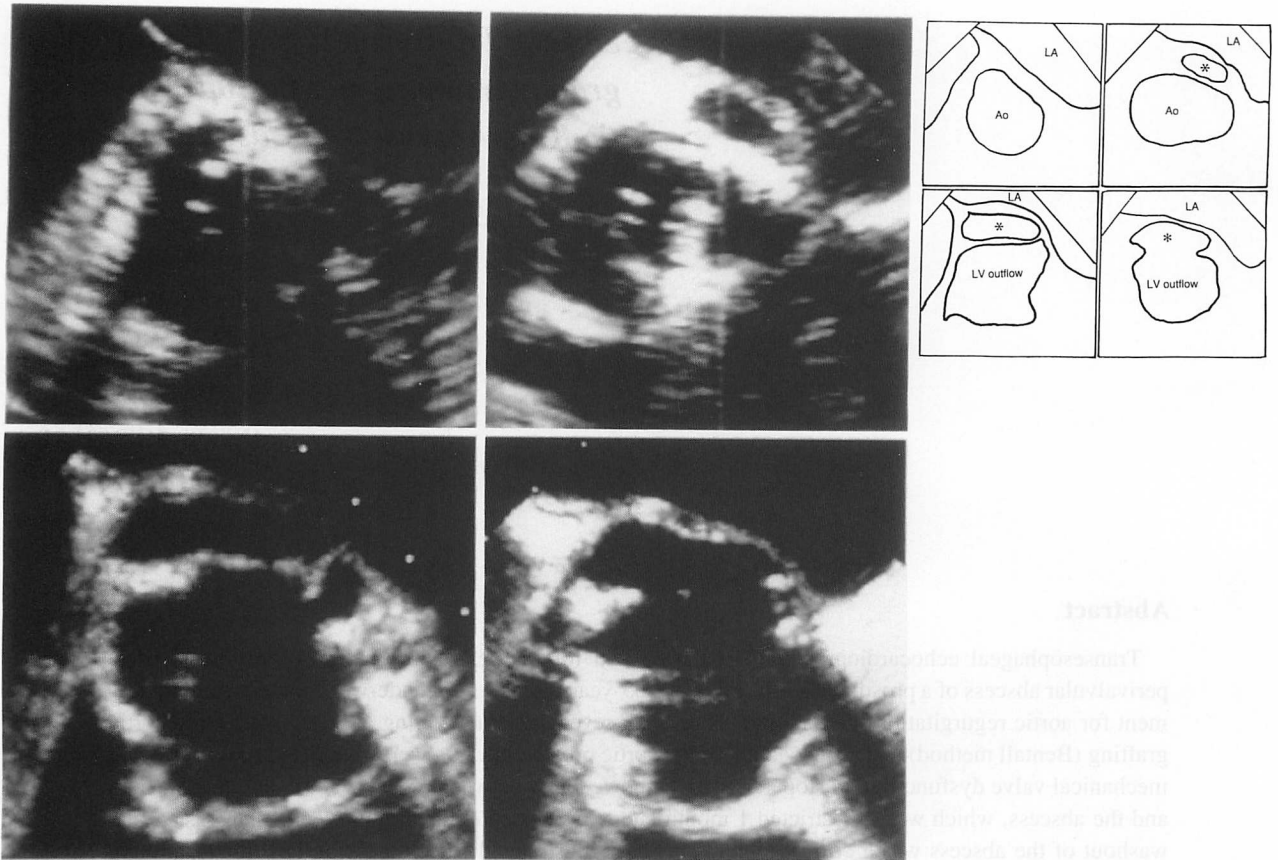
Serial transesophageal echocardiograms (TEE) of the aortic ring abscess
